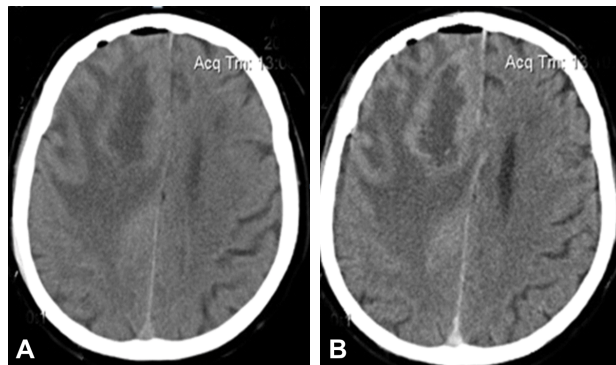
Radiographic features of GB in Case No. 1. Axial brain CT scan (August 2013) demonstrated a right paramedian frontal neoformation, with thick, irregular, minimal enhancing margins, a central necrotic core, moderate peripheral edema, and midline shift: (A) Pre-contrast imaging; (B) Post-contrast sequence at 5 minutes after injection. GB: Glioblastoma; CT: Computed tomography.
